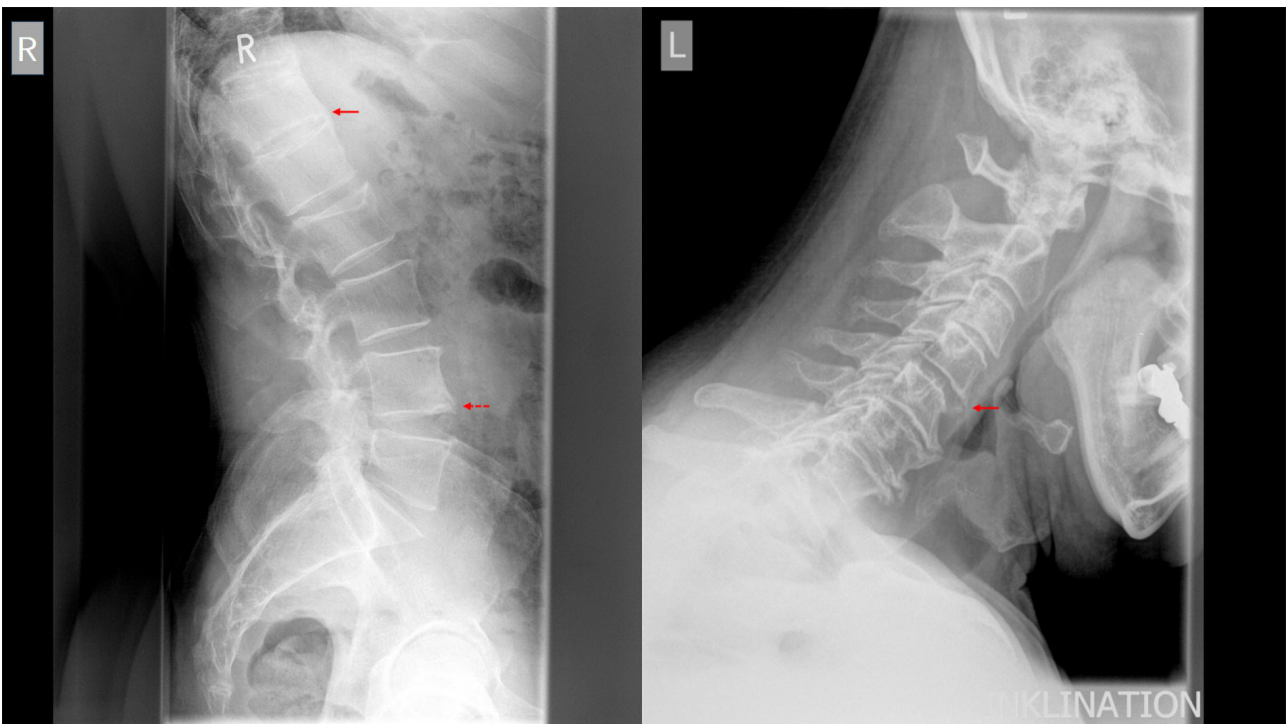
Structural changes in the spine in axial spondyloarthritis (axSpA). Conventional lateral X-ray of the lumbar (R) and cervical (L) spine of a 50-year-old patient with axSpA, showing typical syndesmophytes in the lumbar spine (bridging syndesmophyte—solid arrow, single syndesmophyte—dotted arrow) and rather mixed changes in the cervical spine (arrow shows a syndesmophytes while new bone formation in the segments below is likely to be of degenerative origin, also note height of the intervertebral spaces)
